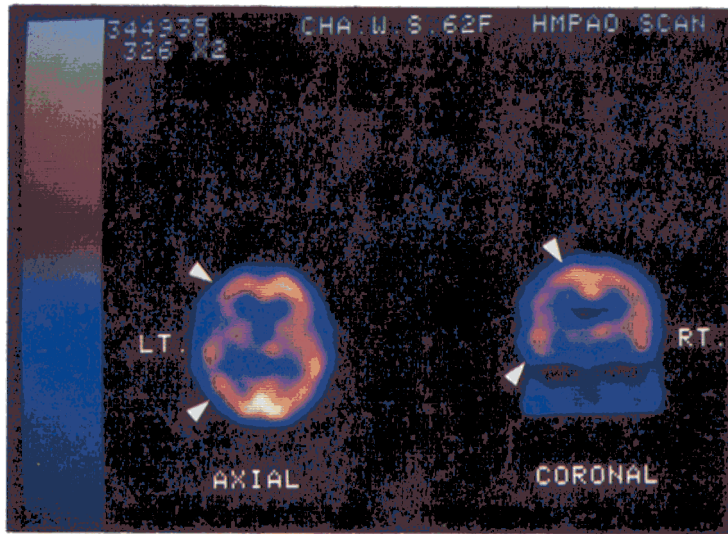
HMPAO SPECT image of the patient 3 demonstrated decreased rCP in the parietotemporal cortex ipsilateral to the thalamic lesion.
